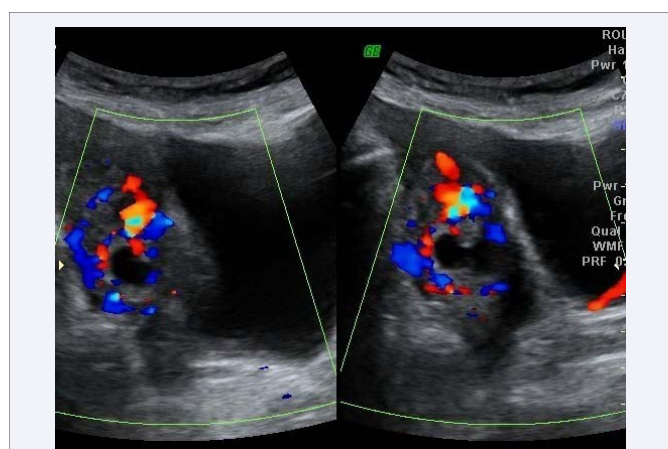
Doppler scan showing increased blood flow in the lower uterine segment.
